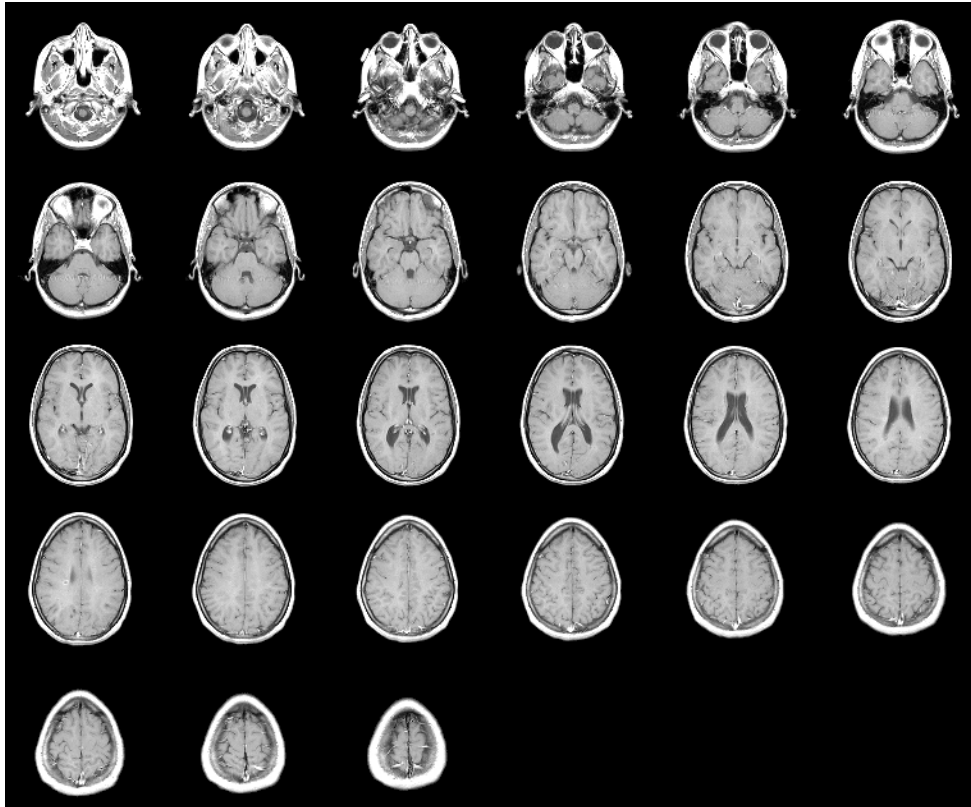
MRI scan showing multiple horizontal slices of a healthy brain (MW, 2022).
